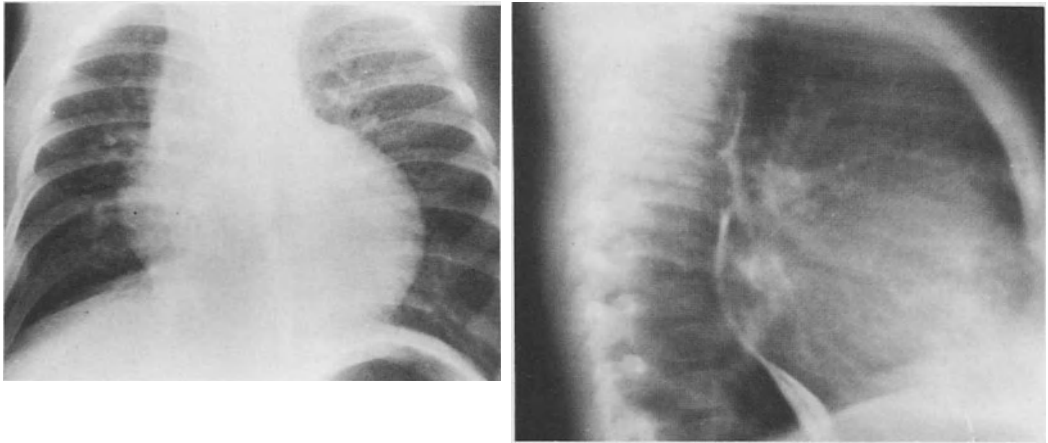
X-rays of the chest in tricuspid atresia with obstruction to pulmonary blood flow demonstrating left ventricular and left atrial enlargement and pulmonary oligemia.
